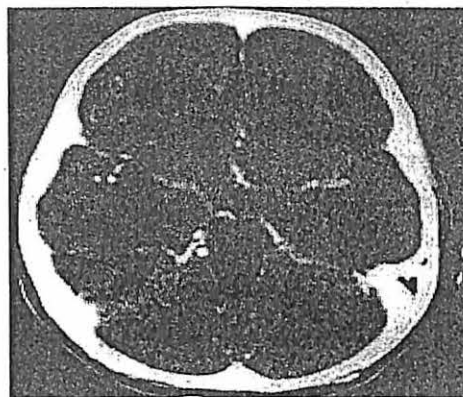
CT scan of patient 1: Presence of meningeal enhancement on the right temporo-parietal region suggestive of meningitis.
